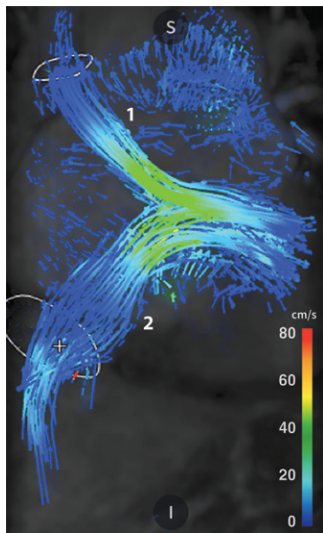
Four-dimensional flow MRI in a 22-year-old woman with Senning circulation. Image with streamlines shows patency of the reimplanted SVC and IVC and absence of stenosis along their course to the mitral valve. 1 = streamlines from SVC, 2 = streamlines from IVC.
